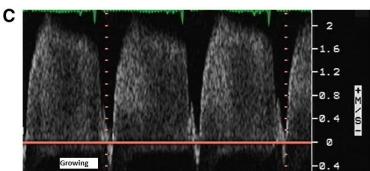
Images from Neocardiolab.com and Echocardiograph for the Neonatologist.
